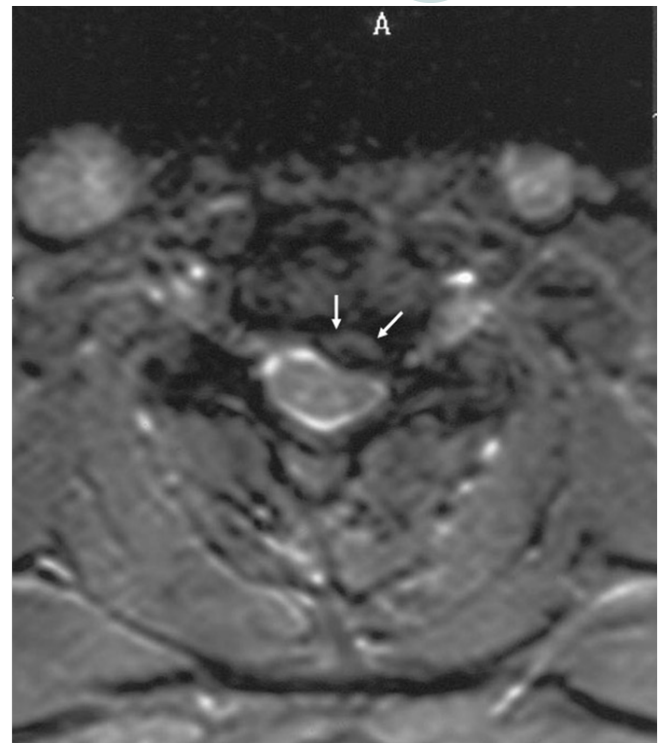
Transverse T2-weighted MRI section through the C5-C6 area showing unchanged the herniated disk fragment compressing the left anterolateral spinal cord (arrows). MRI: magnetic resonance imaging
